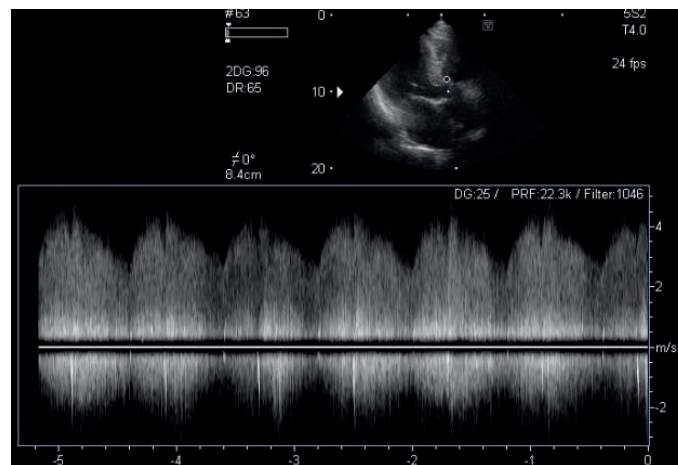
Continuous-wave Doppler of the turbulent flow in the right ventricle The differential diagnosis and which of the following is the correct answer:
